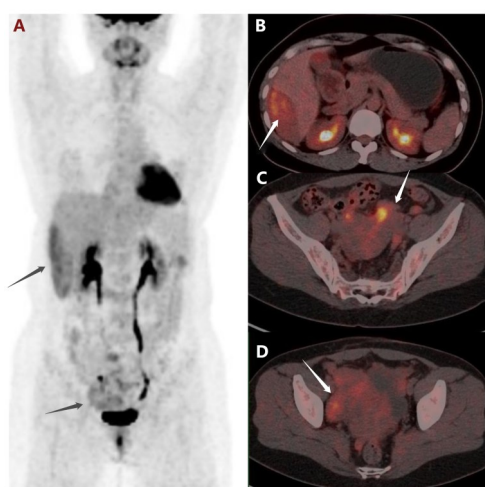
A; The whole-body PET image of case 1. B; DPL nodule in the subcapsular liver and the SUVmax is 3.6. C-D Some DPL nodules near the uterus and the SUVmax is 4.4.
